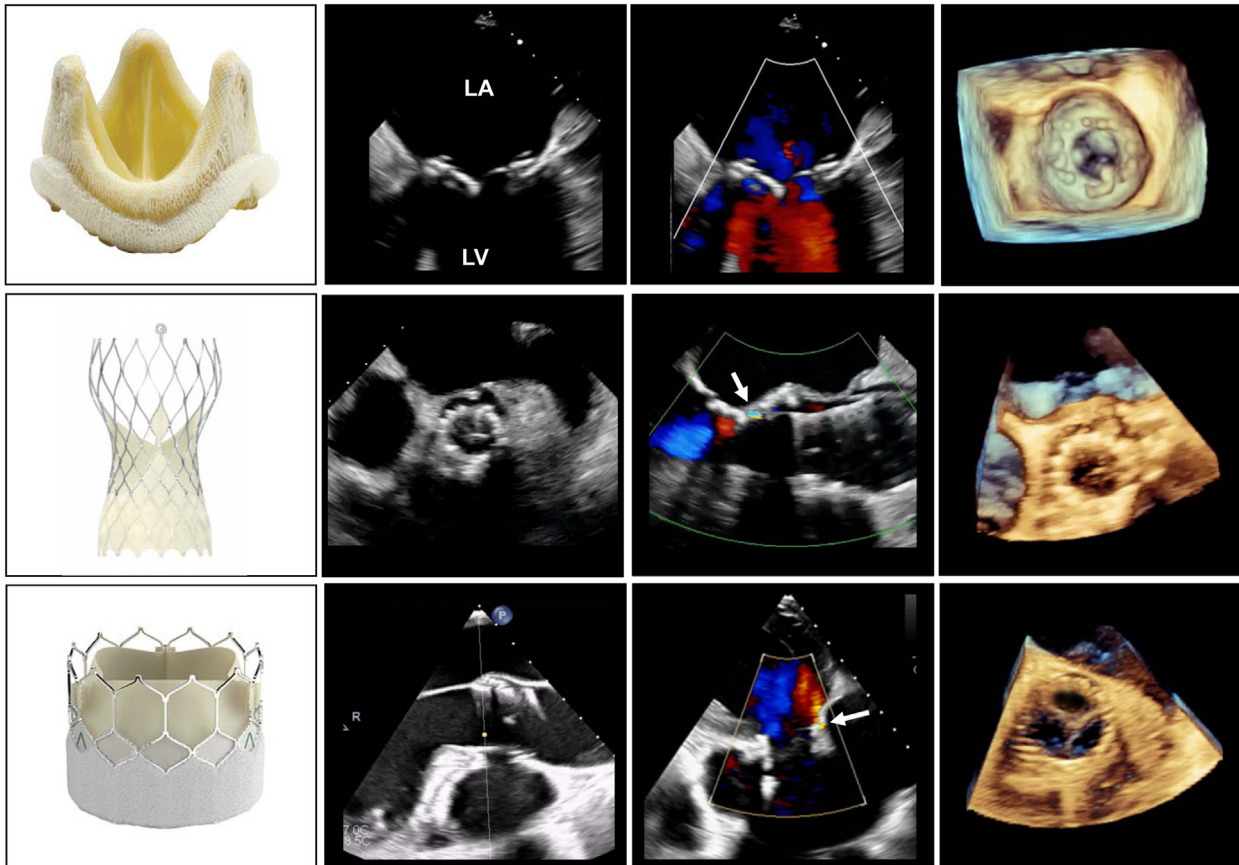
Biological valves: stented (*top row*) and percutaneous valves with their echocardiographic features and 3D transesophageal echocardiographic images. The self-expanding percutaneous valve is in the *middle row*, and the balloon-expandable valve is in the *bottom row*. Mild paravalvular regurgitation is highlighted by the *arrows* in the *middle panels*. LA, Left atrium; LV, left ventricle.
